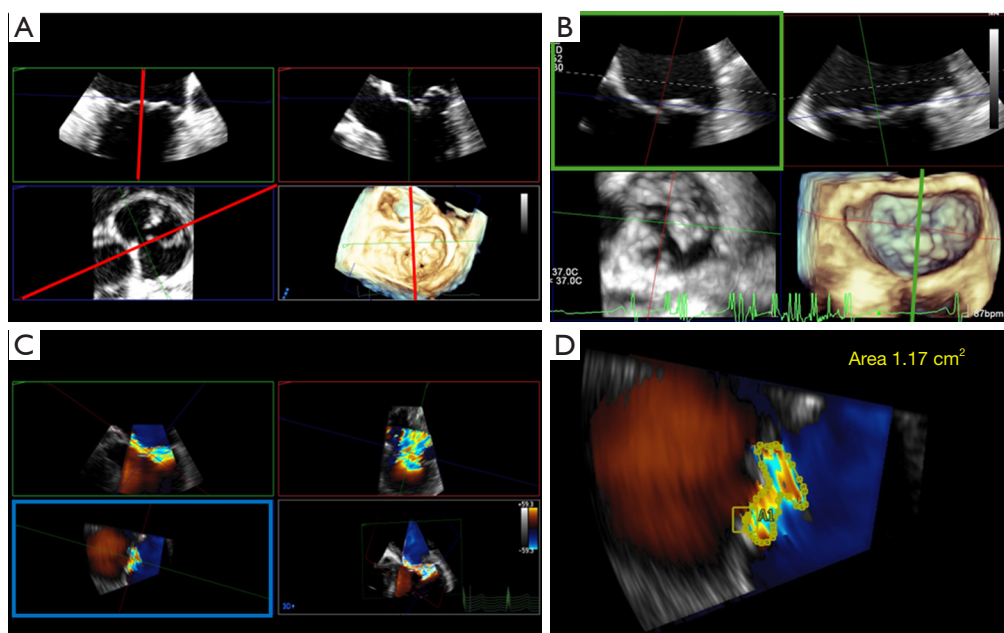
Multiplanar reconstruction of the mitral valve. (A) 3D TEE MPR showing three 2D images (mid-esophageal mitral commissural view, inverted mid-esophageal long-axis view, and en-face mitral valve view) and one 3D rendered-image (surgical view). The red plane transects the mitral valve exactly through the middle of A2-P2. (B) 3D TEE live MPR demonstrating prolapse of P2. The green line transects through P2. The green square shows the presence of P2 prolapse. (C) 3D TEE MPR with color flow Doppler demonstrating mitral regurgitation. (D) 3D TEE MPR with color flow Doppler measuring the 3D vena contracta area of the jet of mitral regurgitation. 2D, two-dimensional; 3D, three-dimensional; MPR, multiplanar reconstruction; TEE, transesophageal echocardiography.
